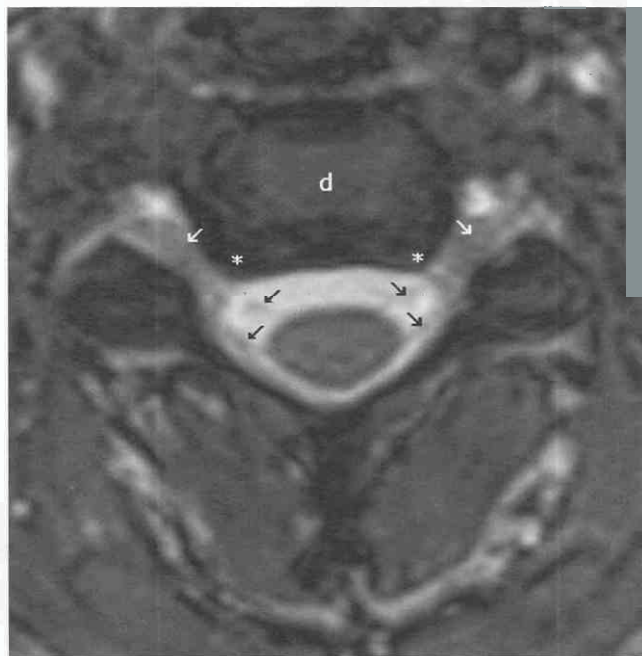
Axial cervical gradient-echo MR image. The exiting nerve roots approach the neural foramina at a 45-degree angle. Both the anterior and posterior divisions can be seen (black arrows); they then join to form the dorsal root ganglia in the foramina (white arrows). Note hypointense uncovertebral joints of Luschka (asterisks) indenting the posterolateral disk (d) margins.
